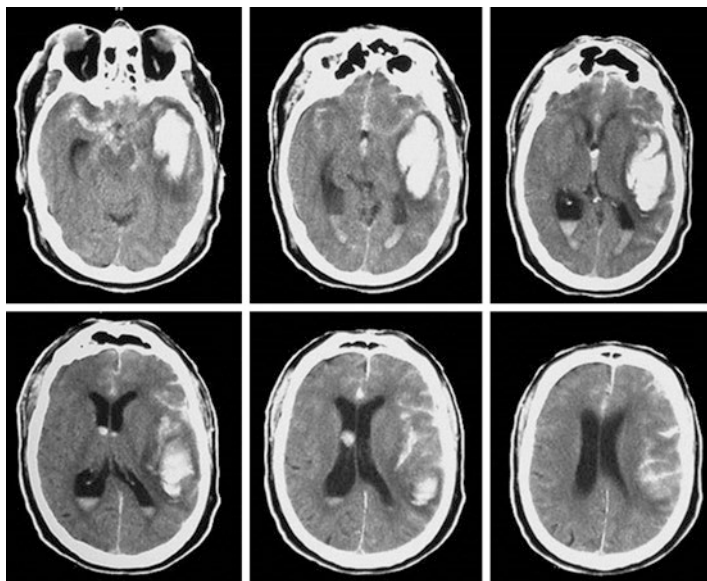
Non-contrast axial CT brain scan showing a left temporal hematoma and widespread subarachnoid and intraventricular hemorrhage. It is obvious that the epicenter of the hemorrhage is in the left temporal lobe, but there is blood everywhere including the right sylvian fissure which confirms that the subarachnoid hemorrhage is pretty continuous from left to right and around the brain surface
